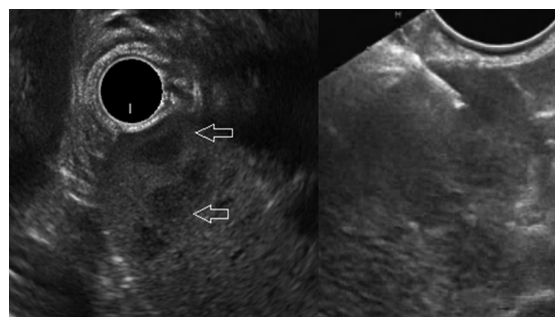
Endoscopic ultrasound (EUS): Focal hypoechoic lesions in spleen and EUS-guided fine needle aspiration (FNA) done from splenic lesions.
